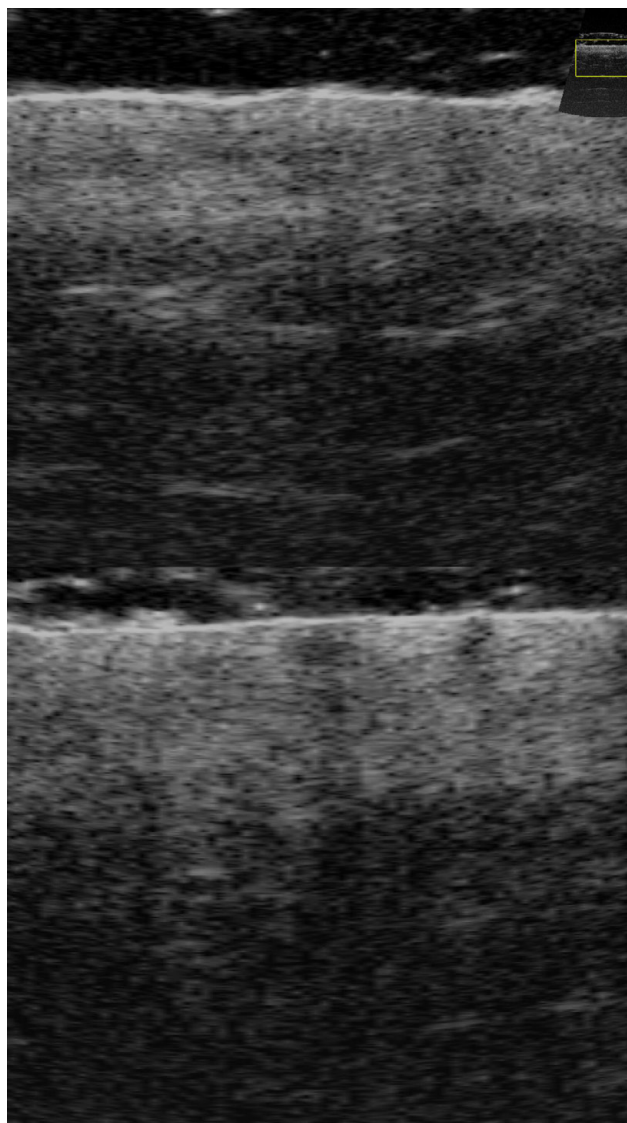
Change in skin ultrasound image. Upper part, photo taken before treatment; lower part – after a series of four treatments with silica bio-microneedles. Source: Own elaboration
